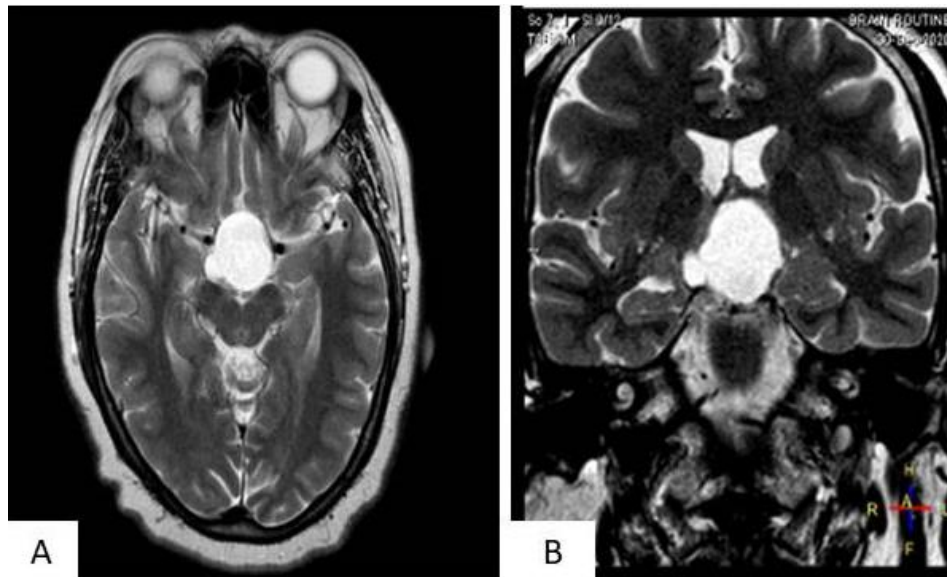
A and B shows MRI of the brain with a cystic lesion in sella extending to suprasellar cistern with mass effect over the optic chiasma and third ventricle
